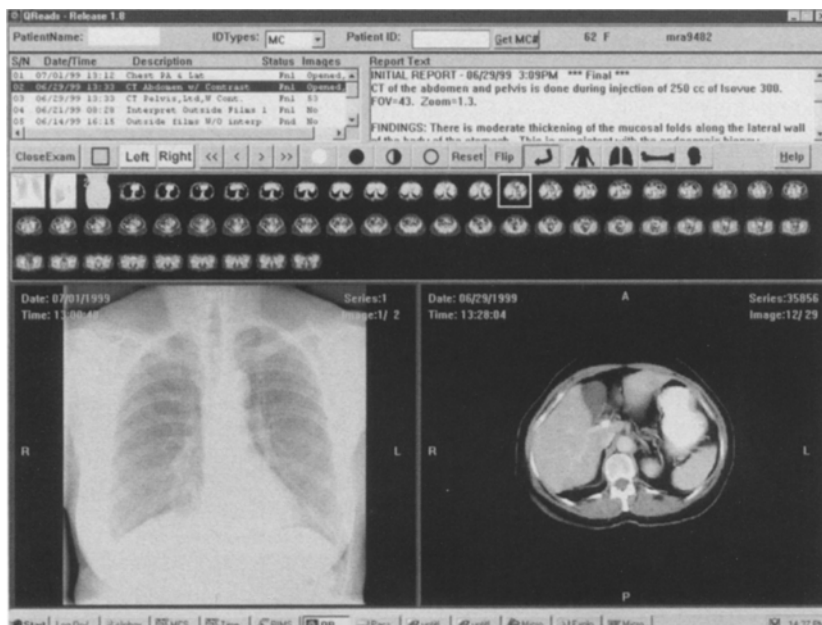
Display application for QREADS. Upper left is listing of all patient exams. Note 2 exams are open. The report for the selected exam is displayed on the upper right. Small snapshots of all images are given, with the PA chest and CT being viewed. Double clicking on any image will give full screen access to the image. Viewer is coupled with the patient's ID.
